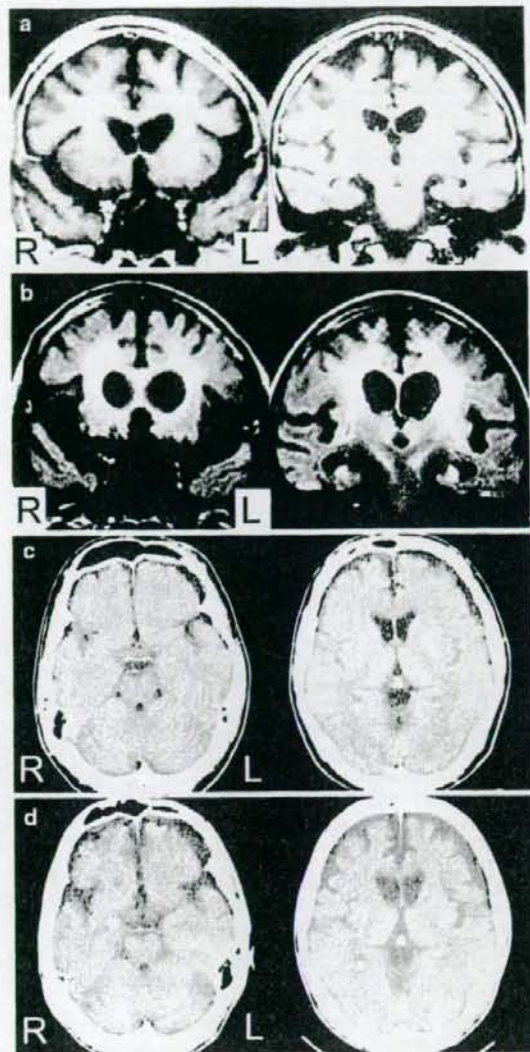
Serial structural images of NIFID (cases 5 and 6). Coronal T1 images 16 months after the onset in case 5 clearly show the atrophy in the caudate nucleus (a). Five years after the onset, the severity of the frontal convexity in case 5 was more prominent in the posterior than in the anterior portion, and the temporal base appears to be spared (b). Serial CT images of NIFID in case 6 show mild atrophy in the frontal lobes and caudate nucleus 4 years after onset (c). The caudate nucleus is already flattened 5 years after onset, but the temporal lobes are relatively spared (d)
